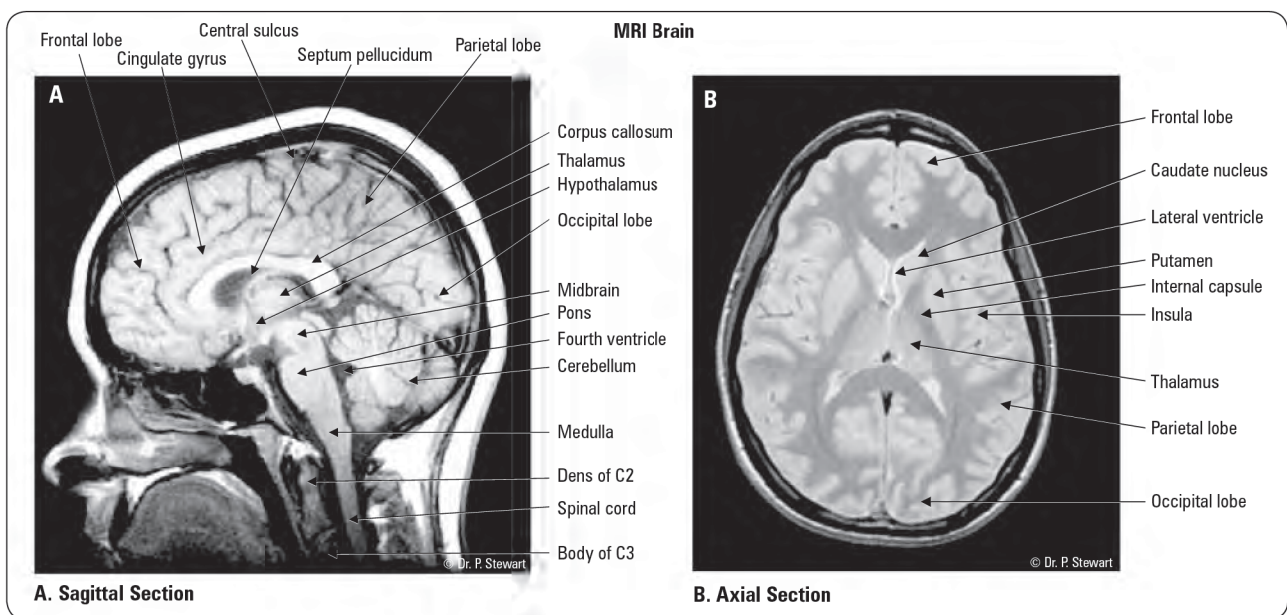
Magnetic resonance imaging (MRI) neuroanatomy
